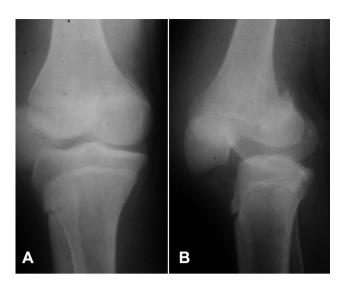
A & B Pre-operative oblique and lateral view radiographs of knee showing bicondylar Hoffa's fracture with patellar dislocation.
